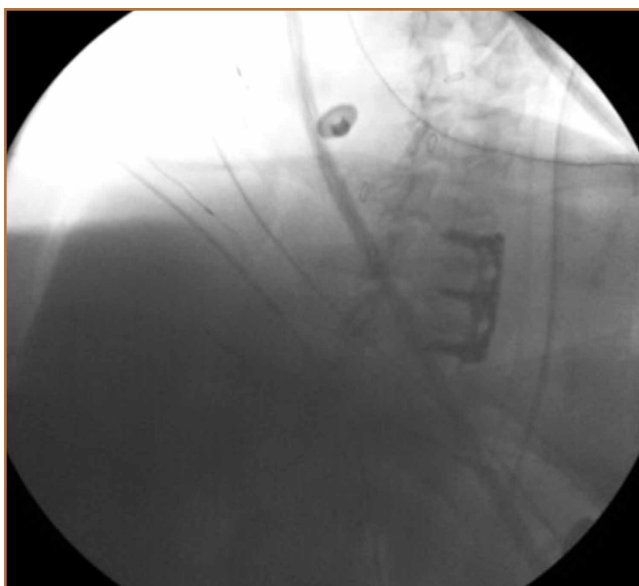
Intraoperative 30°-30° radiograph, showing correct placement of inferior cervical spine hardware.
